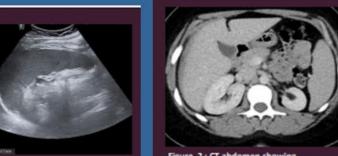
Ultrasound scan showing splenomegaly (14cm)
